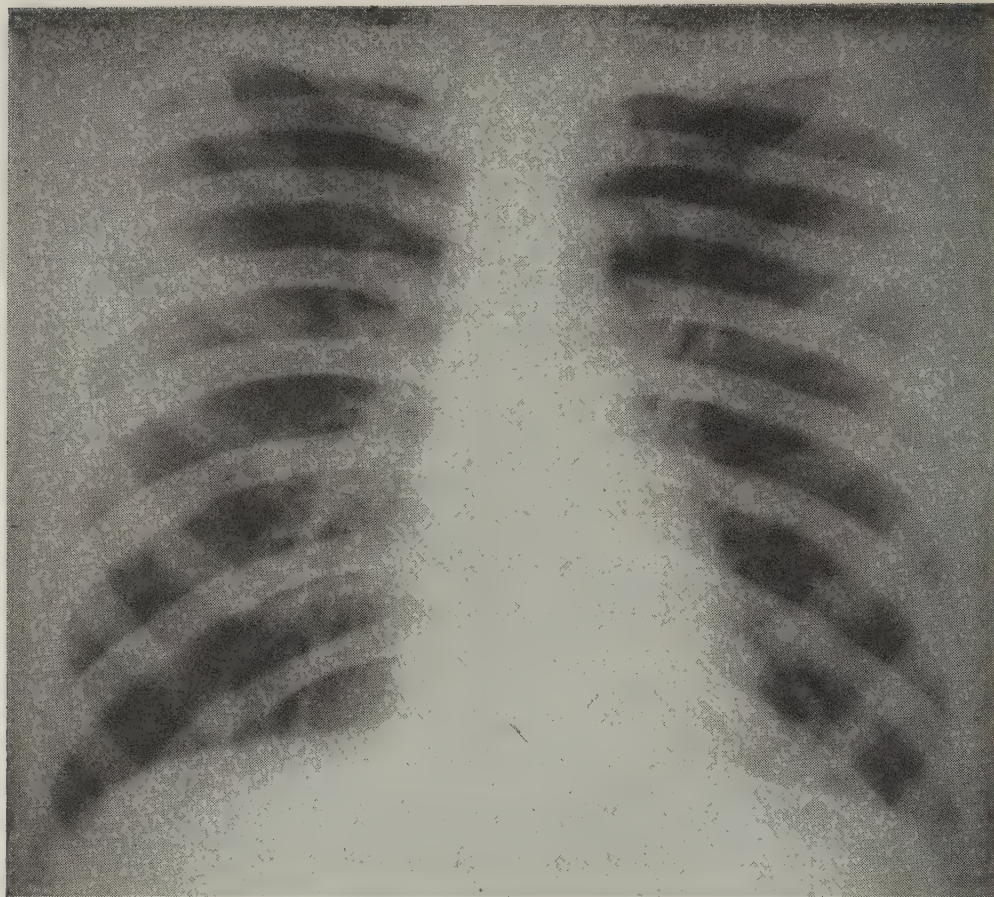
Case 1. Chest roentgenogram at the completion of kanamycin therapy reveals almost complete resolution.
